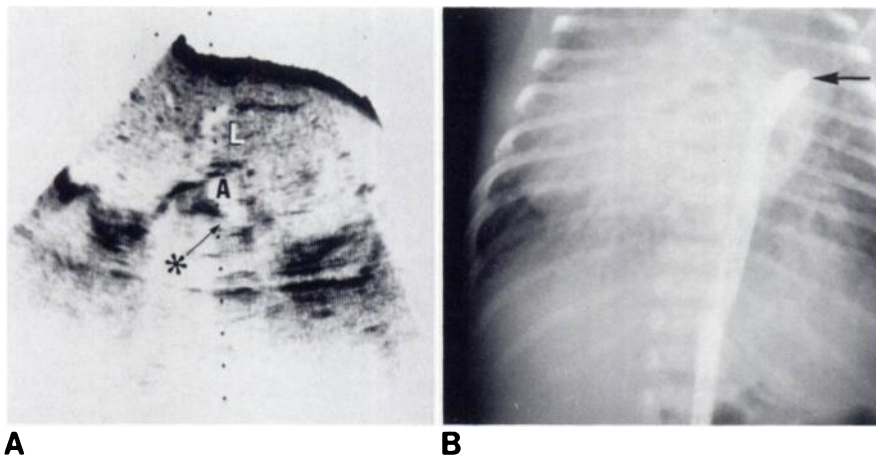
Left isomerism (polysplenic syndrome), case 3, 1 week-old-boy with congestive heart failure and situs ambiguus. A, Transverse sonogram before cardiac catheterization. Large transverse liver (L). Aorta (A) to left of spine and venous structure (asterisk, arrow) presumed to be left inferior vena cava or hemiazygous vein to left below aorta. Normal inferior vena cava not visualized entering atrium. B, Foot vein injection before cardiac catheterization to confirm sonographic findings. Left inferior vena cava with hemiazygous continuation to left superior vena cava (arrow). Polysplenia syndrome with hemiazygous continuation of the inferior vena cava was diagnosed from chest film and abdominal sonogram.
